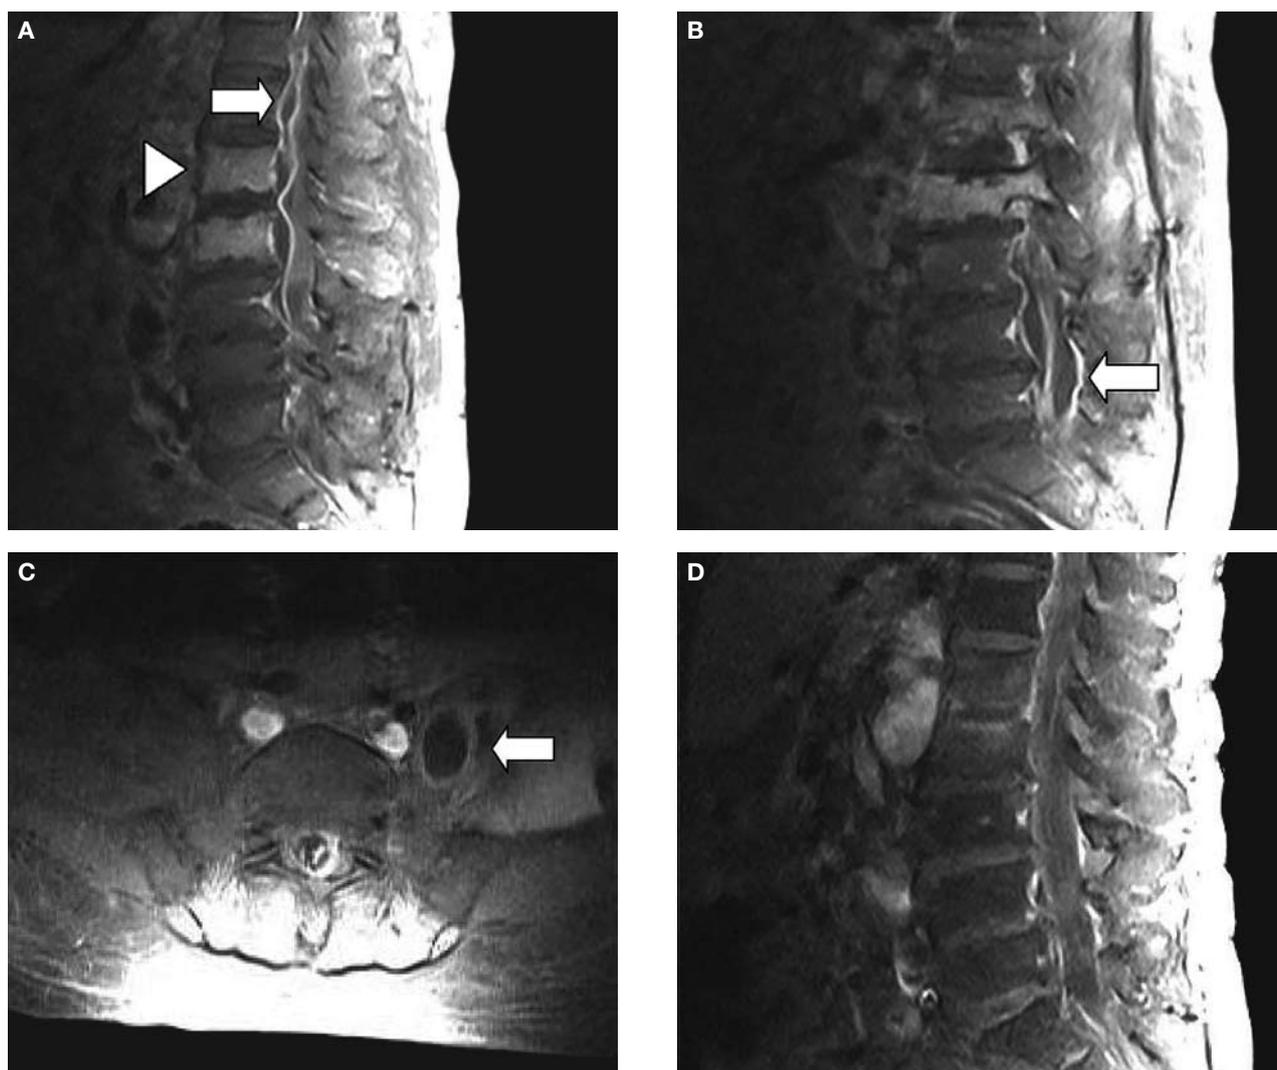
Epidural abscess, spondylitis, and iliopsoas muscle abscess revealed by contrast-enhanced magnetic resonance imaging. On the sixth hospital day, T1-weighted imaging disclosed epidural abscess over the ventral epidural space from T12 to S1 level (A; arrow), and the dorsal epidural space at L4 and L5 level (B; arrow), with compression of the dural sac. There was diffuse enhancement of the L1 and L2 vertebral bodies (arrowhead) without evidence of tumor-like lesions (A), and left iliopsoas muscle abscess was noted at L5 and S1 level (C; arrow). The epidural and iliopsoas muscle abscesses resolved completely before discharge (D).
